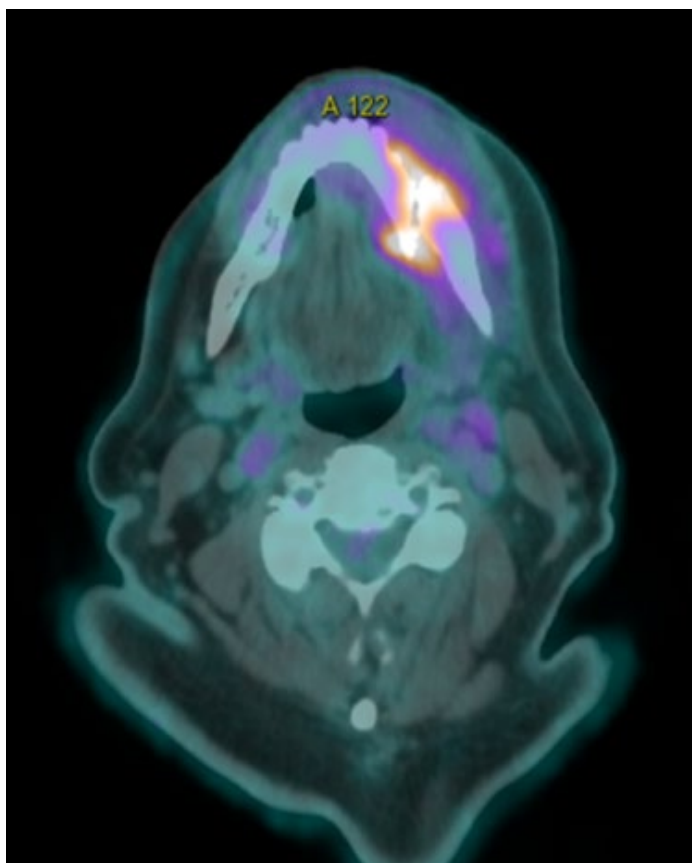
PET-CT scan slice showing hypermetabolism corresponding to the left mandibular fracture involvement, with a SUVmax of 8.6 compared to a hepatic reference of 3.6.
